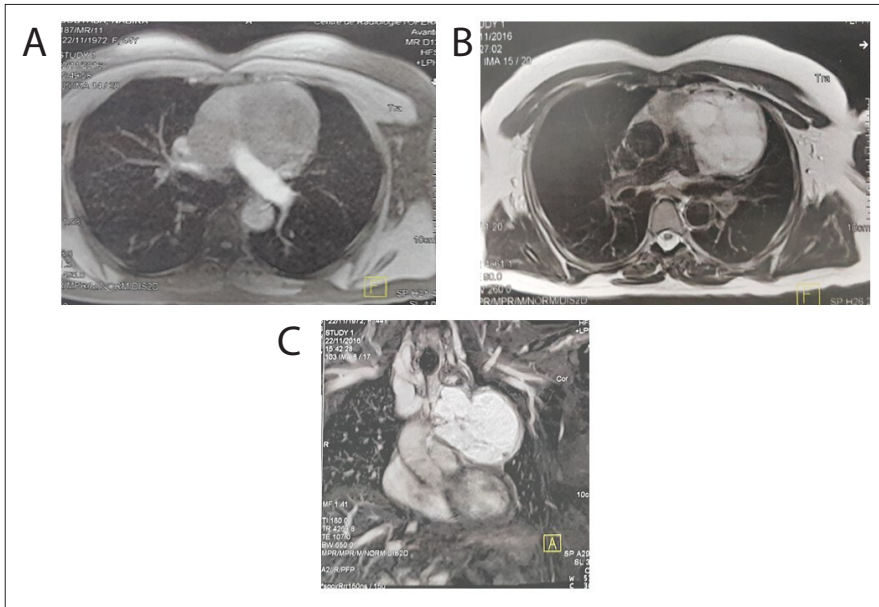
Axial (A, B) and coronal (C) magnetic resonance imaging showing a mediastinal lesion with high T2 signal intensity.
